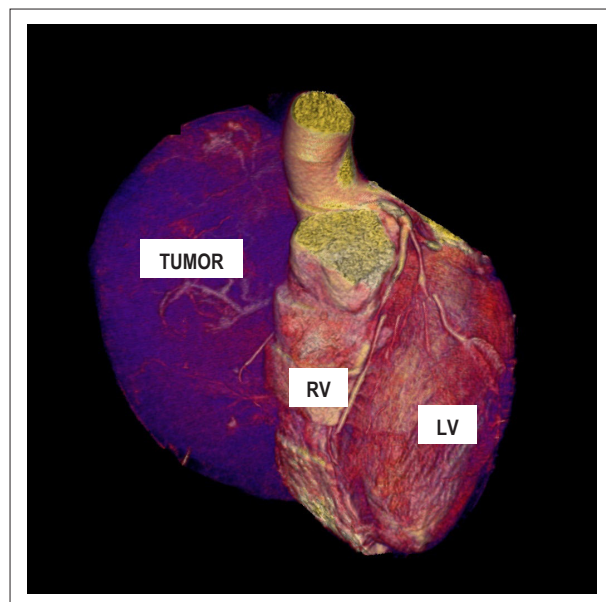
CT of the heart and coronary arteries displaying vascularized mass (arrow) and in close contact with the right chambers. PT: pulmonary trunk; LV: left ventricle; RV: right ventricle.
